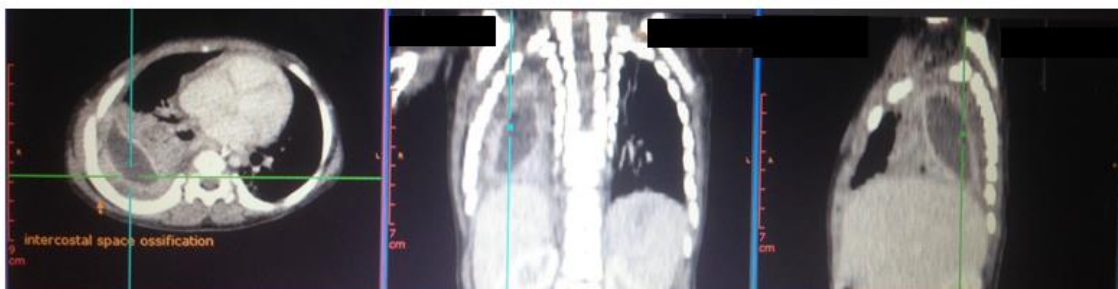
Preoperative CT Thorax which showed a large right pleural collection with collapse right lung
